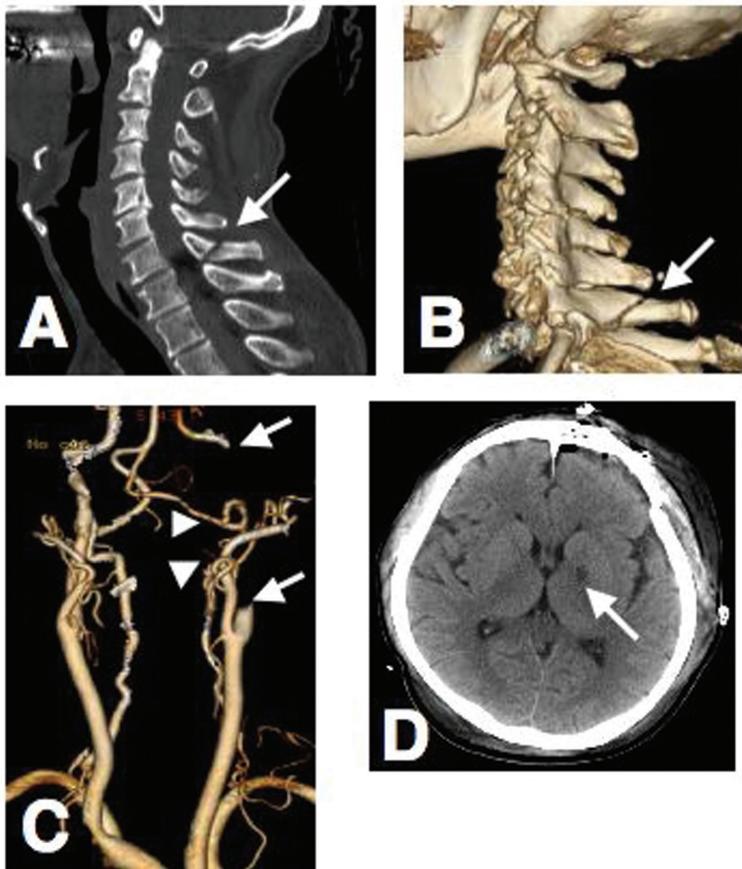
Several imaging studies in a 62-year-old male (case 2). A,B: Cervical spinal computed tomography (CT) sagittal scan (A) and three dimensional (3D)-CT (B) showing spinous process fracture of 7th cervical spine (*arrow*). C: 3D-CT angiogram demonstrating an abrupt discontinuance of left Internal carotid artery (*arrows*) and vertebral artery (*arrowheads*). D: Brain CT axial scan obtained after urgent craniotomy and epidural hematoma evacuation demonstrating a cerebral infarction in the left basal ganglia (*arrow*).
